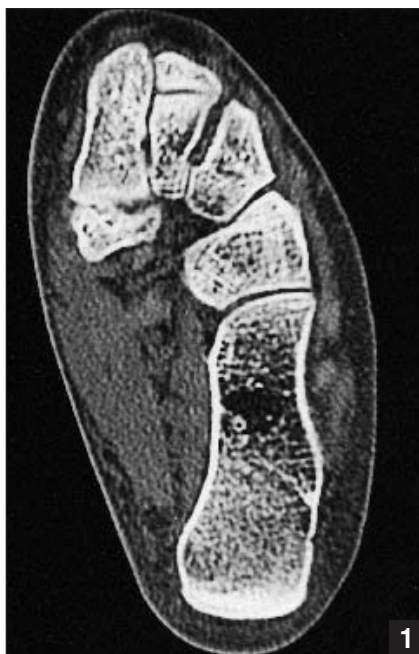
Conventional axial CT of the left foot, showing irregularity, sclerosis, and cyst formation in the first naviculocuneiform joint.
